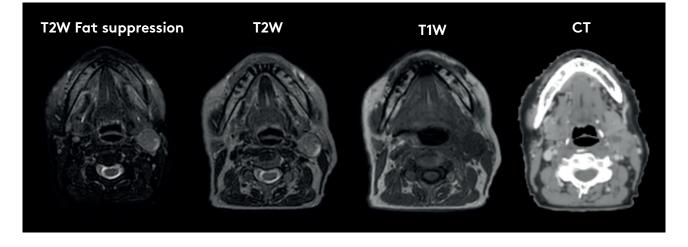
Fat suppression on MR images can visualize targets better on MR compared to non-fat suppressed images or CT images.
